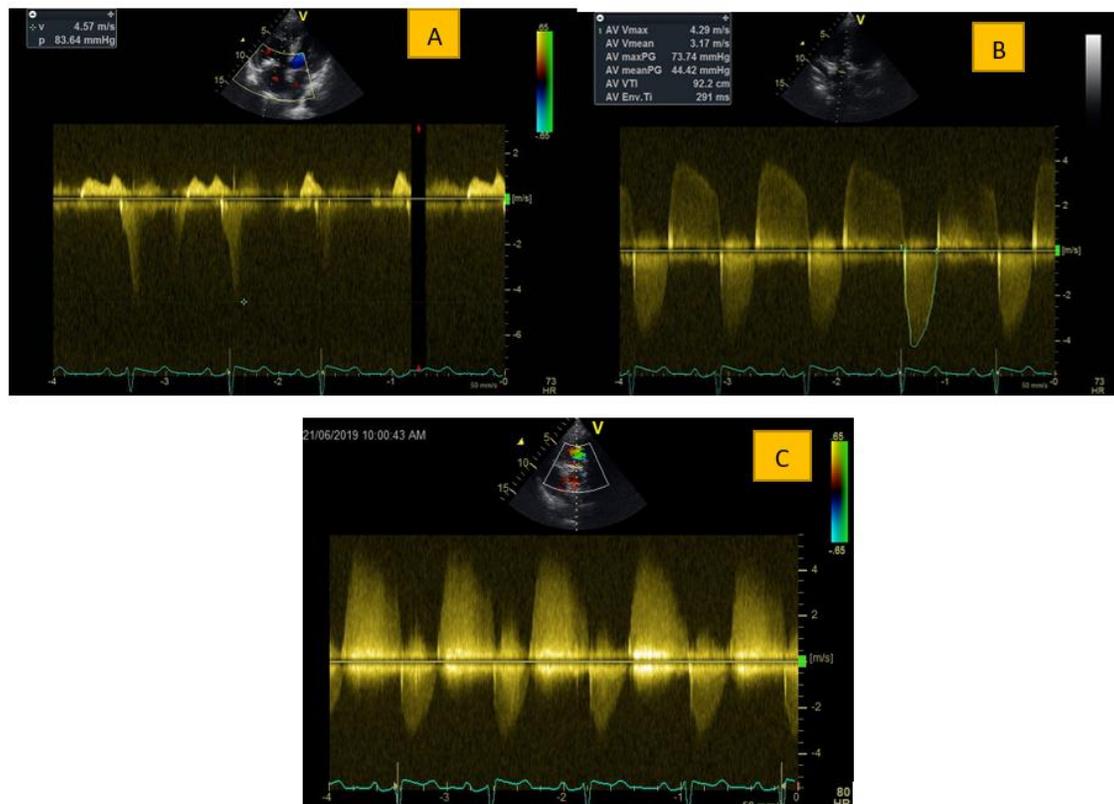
3B, & 3C: Tricuspid regurgitation (TR) Doppler spectrum reveals a TR velocity of 4.5 m/s with a pressure gradient of 83 mm Hg. Doppler across the aortic valve in the apical 5-chamber view shows the gradient of severe aortic stenosis, and Doppler across the pulmonary valve shows a mild gradient.
